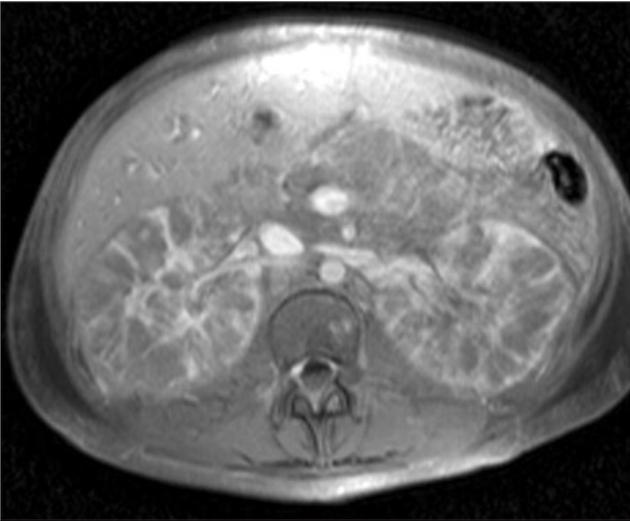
MRI of abdomen.
